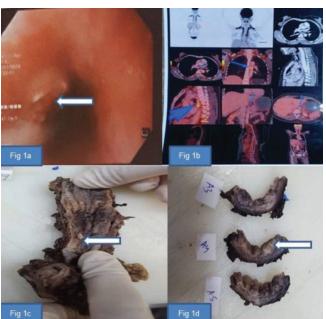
1a-1d: Fig 1a: Gastroesophageal endoscopy with a polypoidal ulcerated growth in the oesophagus. Fig 1b: PET-CT showing metabolically active asymmetric enhancing mural thickening at middle oesophagus. Fig 1c and 1d: Gross image revealing a greyish brown nodular growth in the mid oesophagus.
